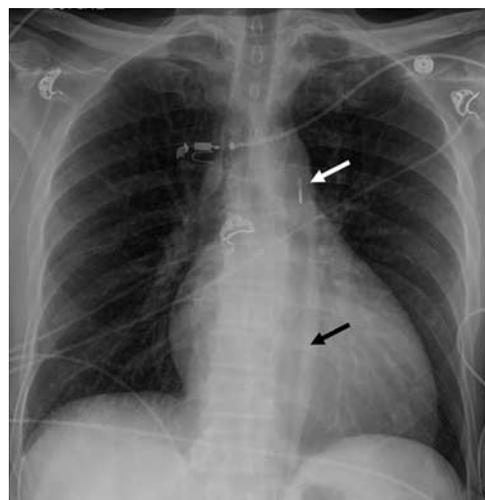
IABP: frontal radiograph depicting inflated IABP. Note the tip marker just below the aortic arch (white arrow), distal to the left subclavian artery take off. The inflated balloon (black arrow) is incidentally visualized.
